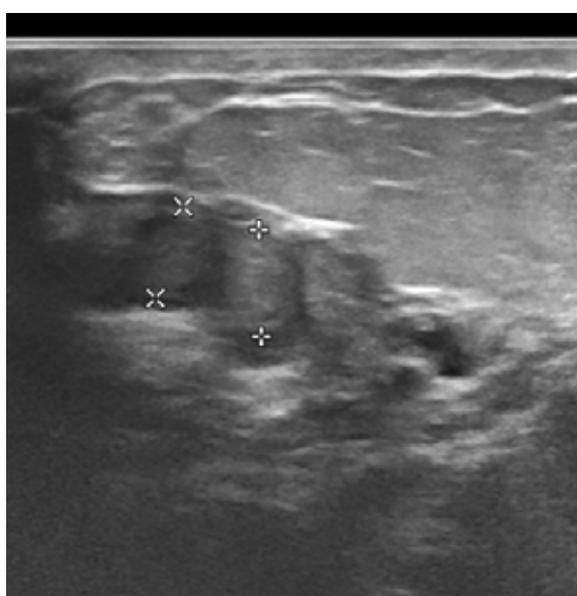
Intraductal papillomatosis. Ultrasound image shows a dilated duct filled with hyperechoic material.
